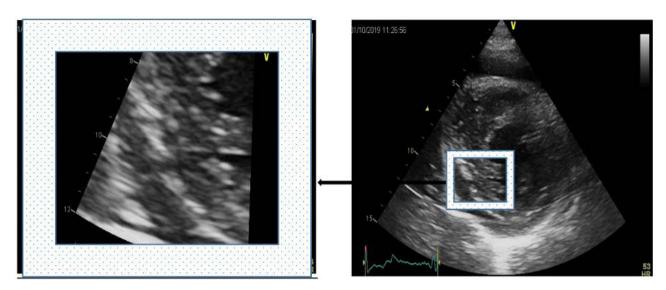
The echocardiography showed the rupture of the heart wall with pericardial effusion.
